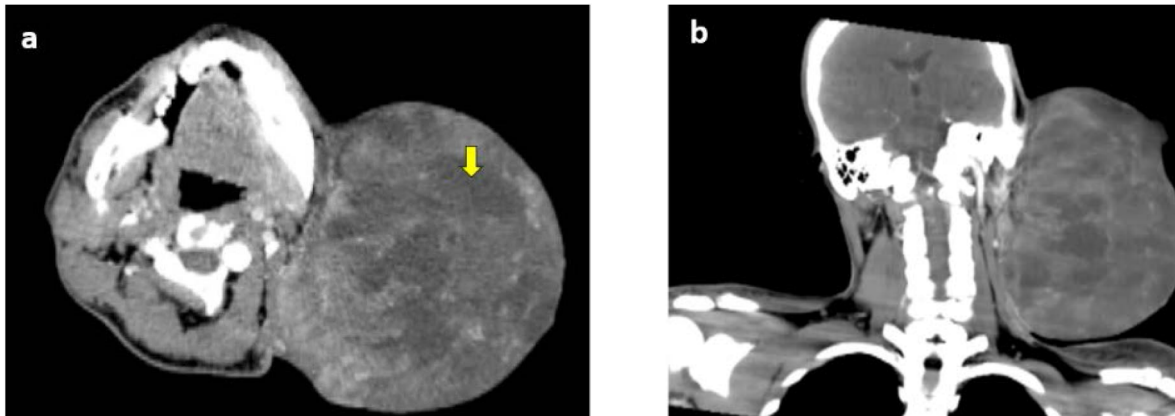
Heterogenous enhancing mass measuring 15.8 cm × 13.3 cm × 18.8 cm in (A) axial and (B) coronal view of contrasted CT neck. Areas of hypodensity (arrow) likely represent necrotic components.
